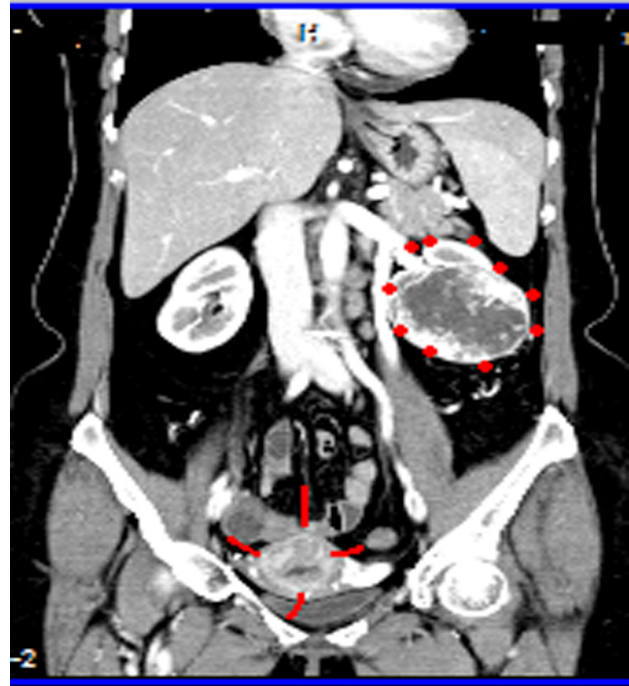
CT scan image of uterus and left kidney. Uterus marked by red arrows and left renal mass marked by red dots
